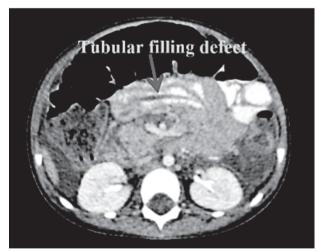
CT Scan with Contrast Shows a Tubular Filling Defect Raising the Possibility of the Presence of a Worm (Arrow)
